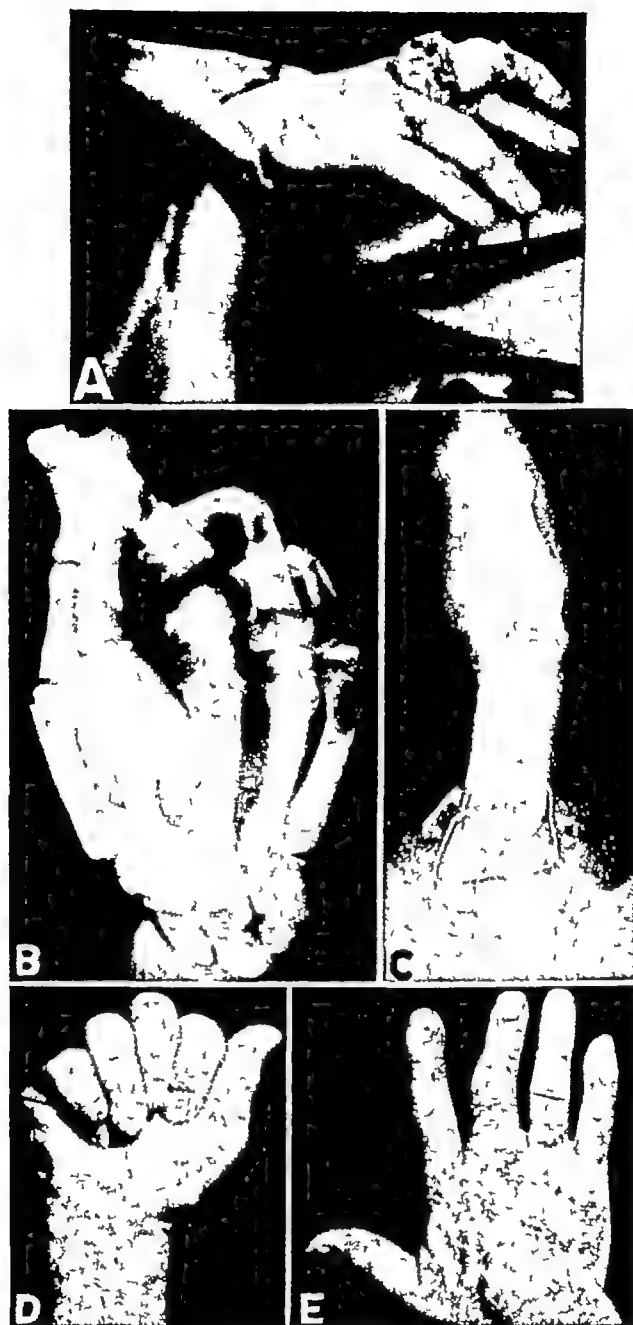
A*, finger almost cut off by ventilating fan, open fracture and tendon and nerve injury *B*, original x-ray *C*, after treatment by immediate open reduction and internal fixation with wire *D* and *E*, end result, showing good function despite slight angulation at fracture site due to loss of bone
